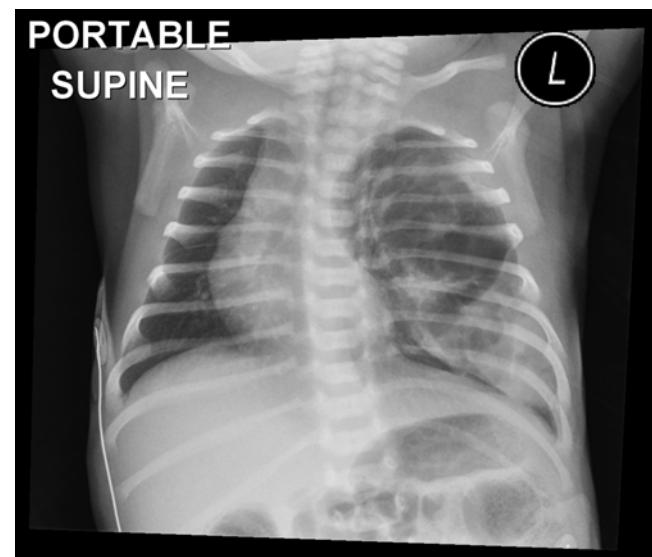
Congenital cystic adenomatoid malformation. Chest radiograph in a neonate with a left-sided amorphous cystic mass filling most of the left hemithorax. The cardiac silhouette is shifted to the right. The right hemithorax is slightly opacified
